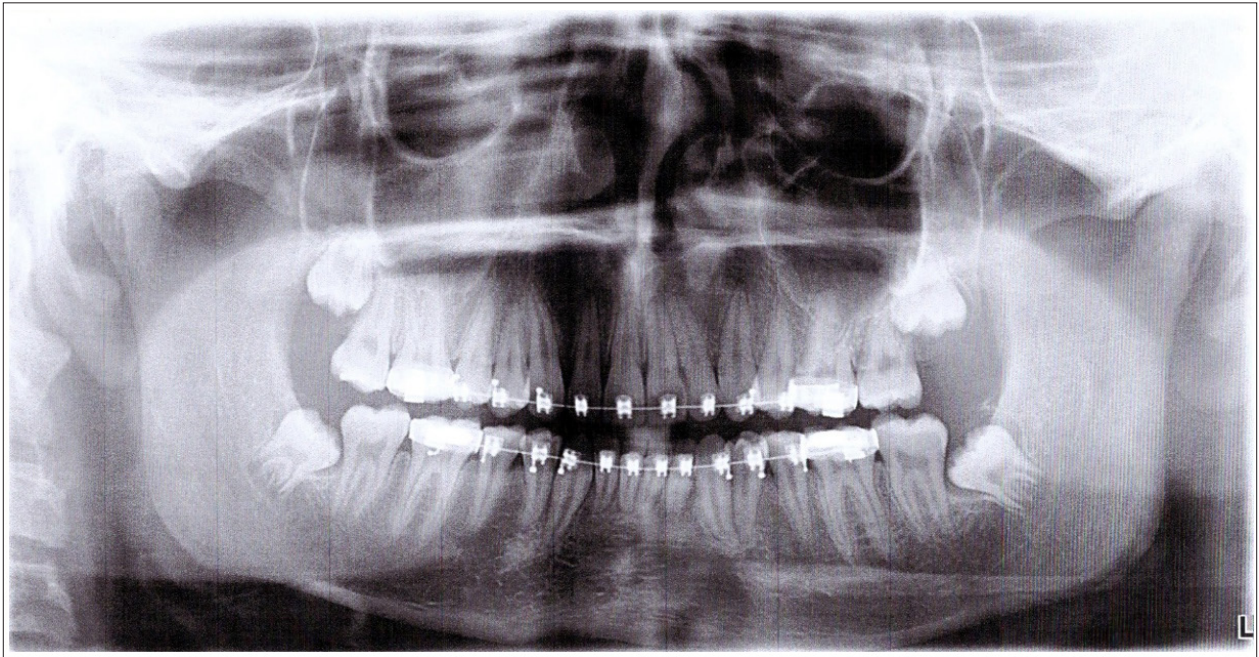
Final stage panoramic X-ray(a), Lateral cephalometric(b) and CBCT(c)
